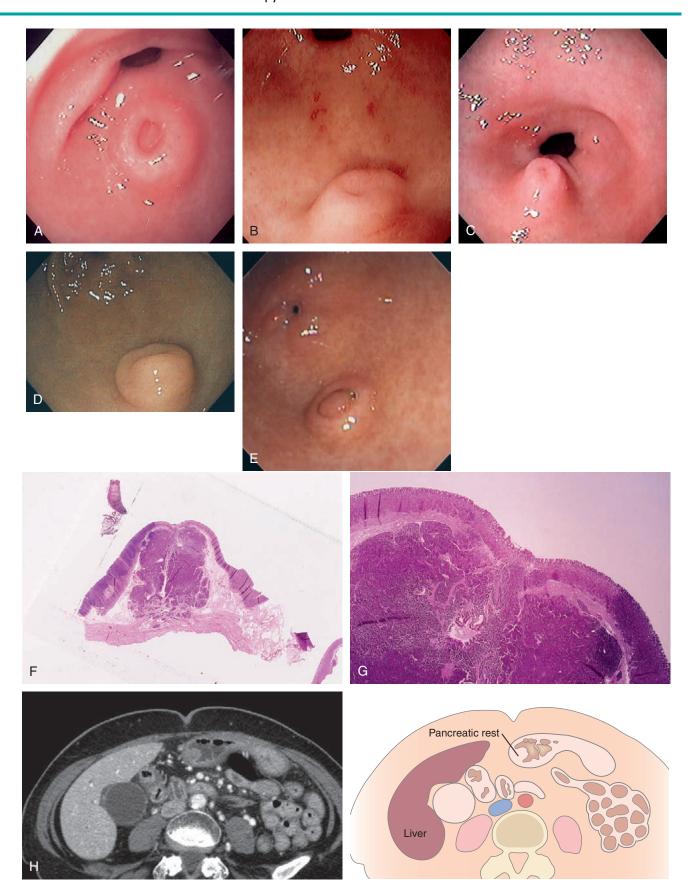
PANCREATIC REST Variable appearance of a pancreatic rest (A-E). F, G, Pancreatic tissue present in this submucosal lesion. H, CT scan shows a small lesion corresponding to D.
